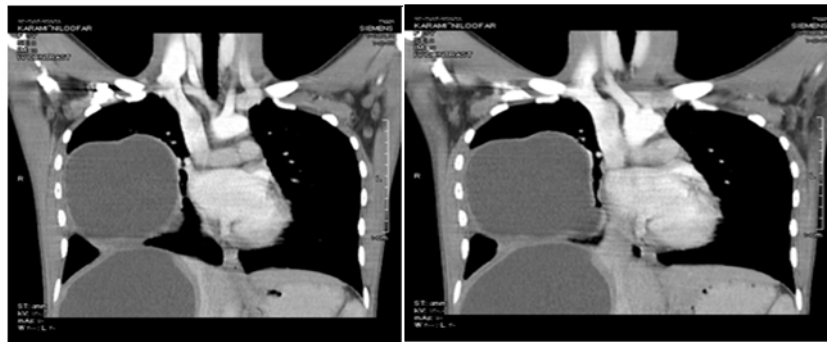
Coronal section of thorax and abdomen CT scan
